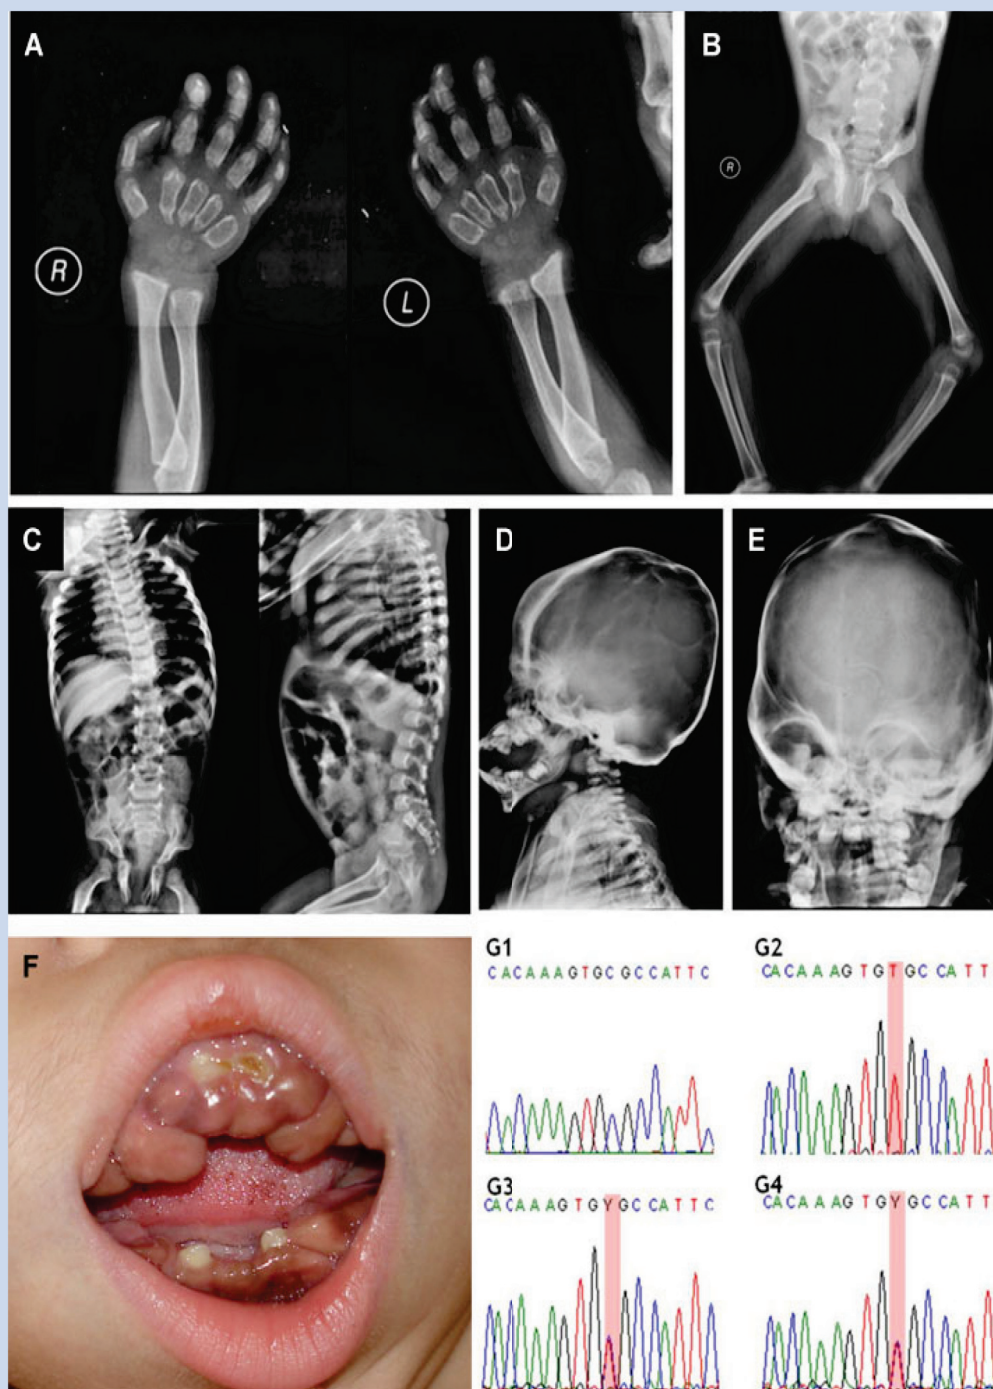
Phenotypic and genotypic aspects of the patient. A–E: Radiographs taken at age 3 showing dysostosis multiplex: Thickened skull bones, oar shaped ribs, dysplasia of pelvis, anteroposterior shortening of vertebral bodies, diaphyseal widening of radius and ulna, and remodeling deformity of metacarpals and phalanges. There is delay in ossification of carpal bones. F: The patient showing severe gum hypertrophy. G: Electropherograms highlighting the affected residue of control individual (G1), patient (G2), and his parents (G3–mother; G4–father).
